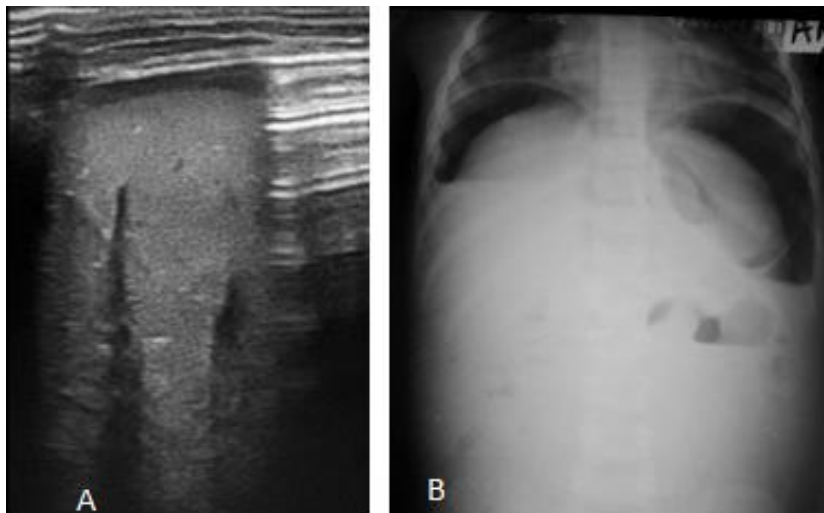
A Longitudinal US image in a 7 month old patient who presented with a 4 day history of generalised abdominal pain, constipation and fever show linear area of increased echogenicity with distal ring-down reverberation artefact indicative of free peritoneal air. B Erect abdominal X-ray show air under the diaphragms.
